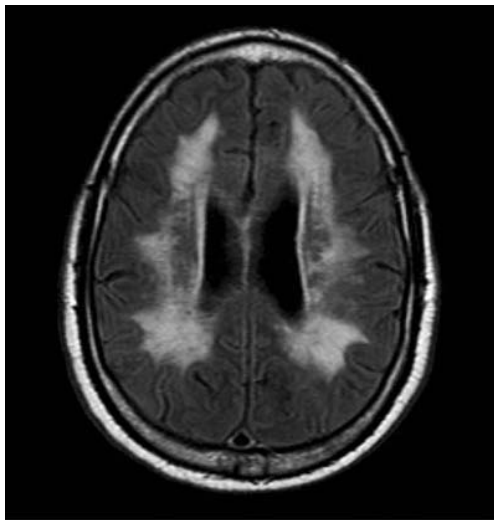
Brain MR: FLAIR sequence demonstrating diffuse hyperintensities of the periventricular white matter.
